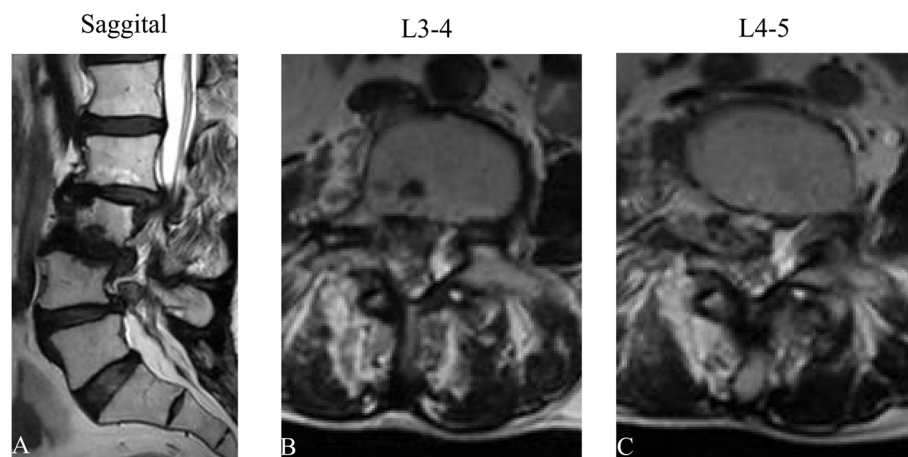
MRI median sagittal and cross-sectional scans (A/B/C) revealed L3–4 and L4–5 spinal stenosis, dural sac compression, redundant nerve roots, and nerve root sedimentation signs (+); in the sagittal view (A), the L3–4 disc indicates downward prolapsed, and the L4–5 disc indicates upward prolapsed; transverse scans reveal the upper endplate layer of L4 (B) and the lower endplate layer of L4 (C)
